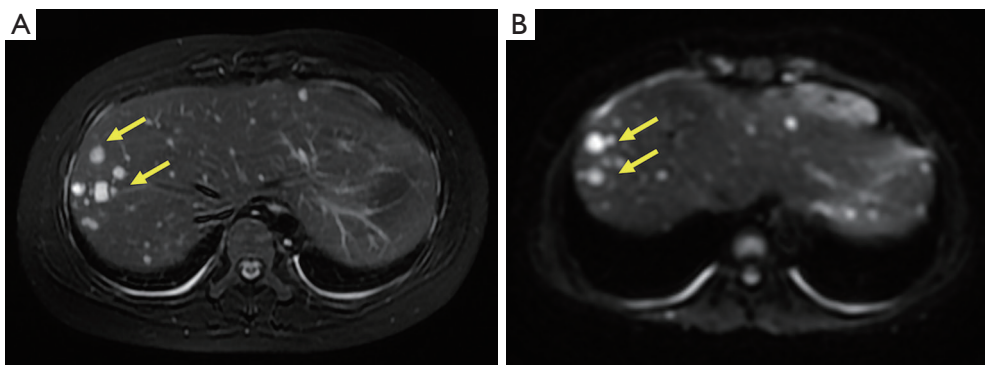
MRI before definitive diagnosis of the patient. Different sizes nodules were located mainly in the right lobe of the liver and subcapsule of the liver but not along the portal vein. The lesions were more obvious in MR from the macroperspective. (A) Multiple nodules with high signal in T2-weighted imaging are highlighted by yellow arrows. (B) Multiple nodules with high signal in diffusion-weighted imaging are highlighted by yellow arrows. MRI, magnetic resonance imaging; MR, magnetic resonance.
